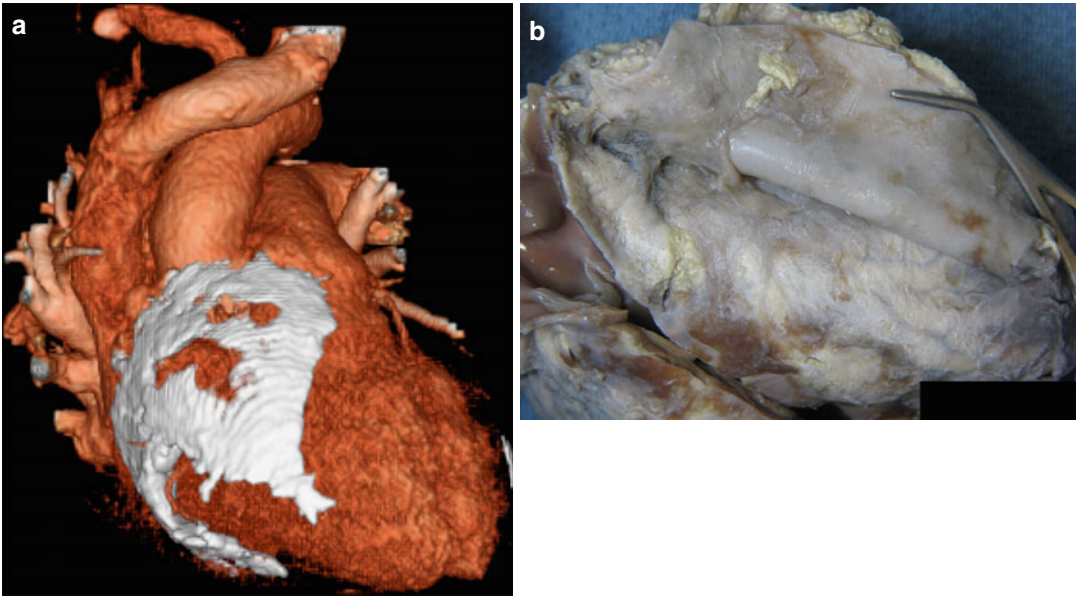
Radiation pericarditis. (a) CT 3D volume rendering of substantial calcification of the pericardium in a patient with radiation induced constrictive pericarditis. (b) Radiation induced constrictive pericarditis in a patient with Hodgkin's disease. The thickened and calcified parietal pericardium is artificially folded outward to demonstrate an elaborate network of adhesions and thickening
